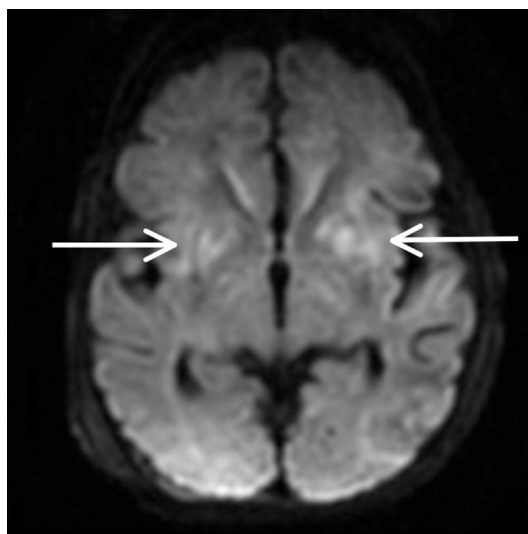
Diffusion-weighted MRI (axial) image showing basal ganglia injury (arrows).
